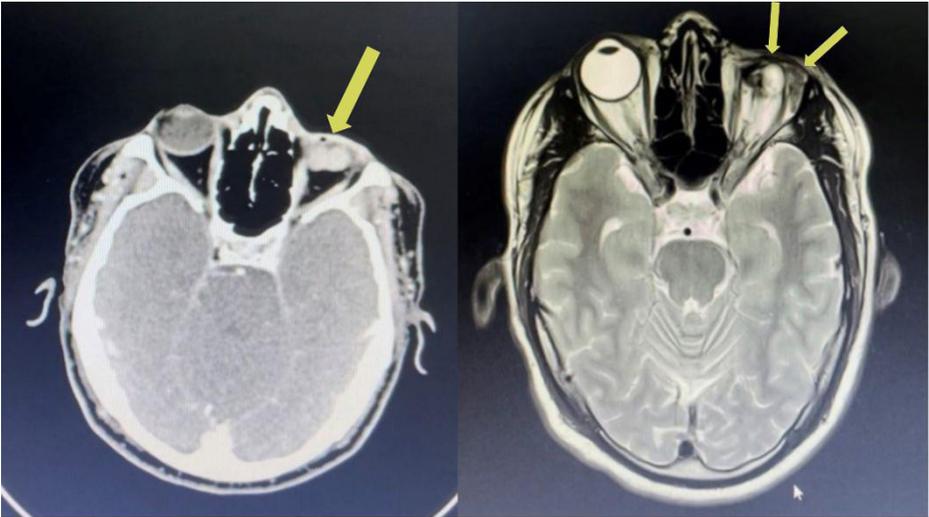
(Left) CECT axial view of the orbits showing a lobulated heterogeneously enhanced mass (yellow arrow) at the left orbital region and thickening of overlying skin. (Right) T2W MRI axial view of the orbits showing loss of normal left globe configuration and lobulated mass measuring 1.5 x 1.1 x 1.0 cm, and a bulky left lacrimal gland (yellow arrows).
